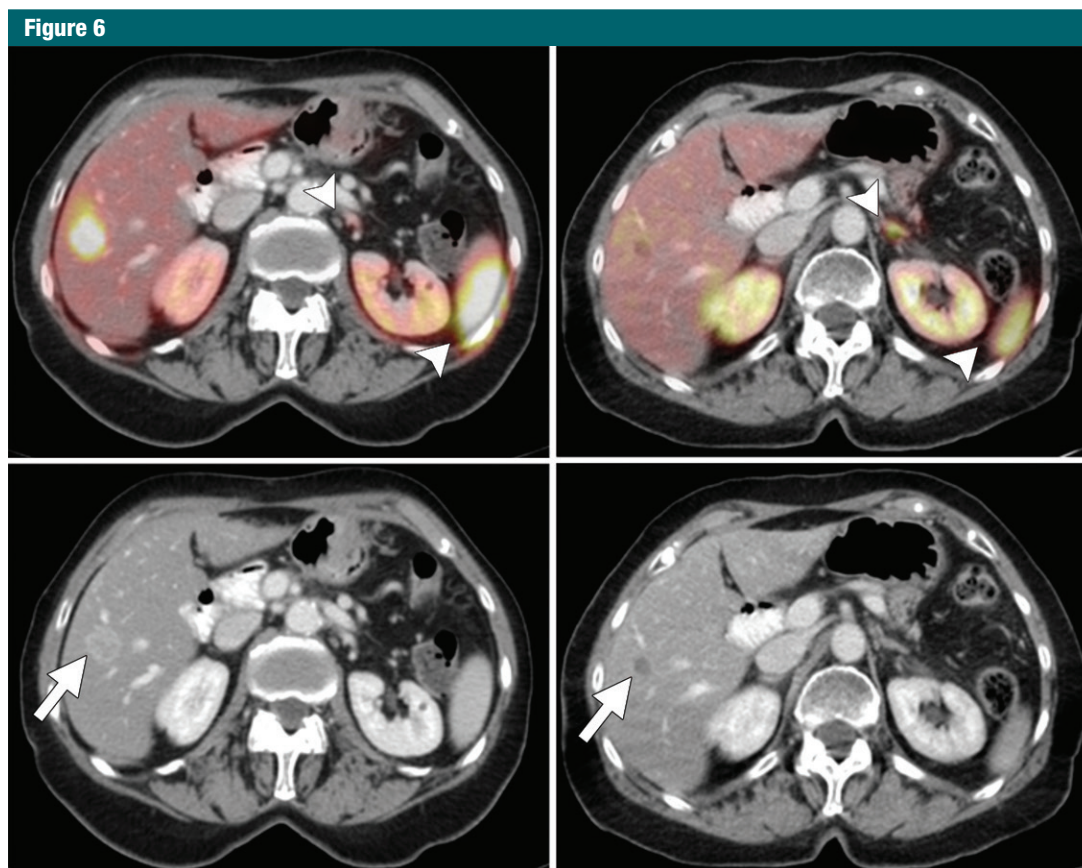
Gallium 68 dotatate PET/CT (top) and CT (bottom) images before (left) and 10 months after (right) the start of treatment with Lutetium 177 dotatate for metastatic neuroendocrine tumor. CT images show a marked decrease in the size of the metastasis (arrows) and resolution of contrast enhancement after treatment. PET shows almost complete resolution of focal tracer uptake of the metastasis. Arrowheads indicate physiologic uptake by the spleen and left adrenal gland. (Images courtesy of Dr Wolfgang Weber.)
